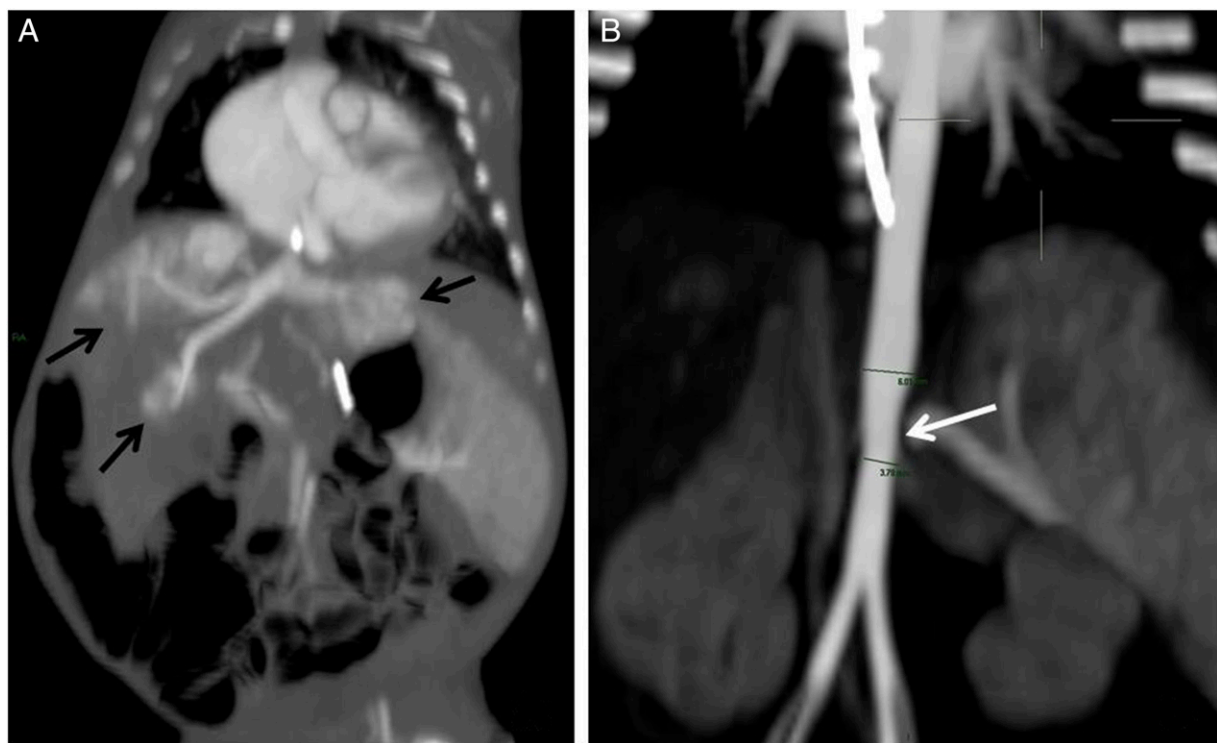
Computed tomography scan. A. Black arrows indicate locations of hepatic hemangiomas. B. White arrow demonstrates aortic tapering below celiac trunk.
